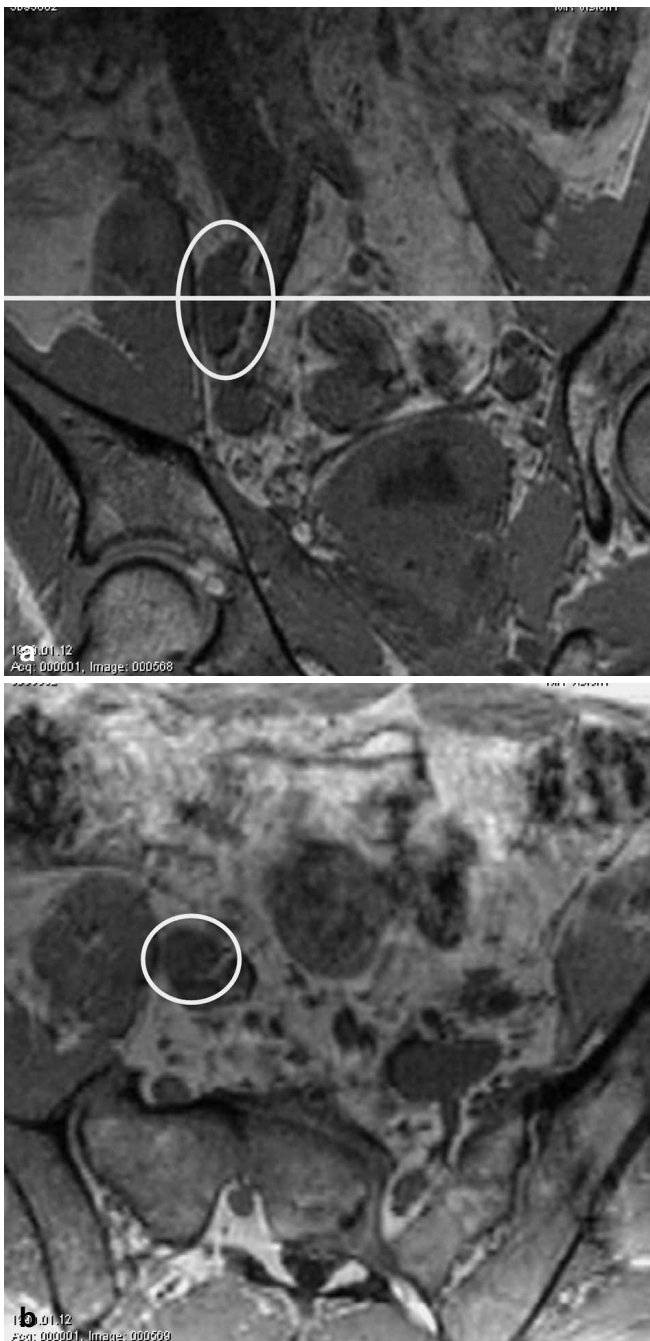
a, b. Three-dimensional T1-weighted MR images in oval enlarged lymph node metastases. Three-dimensional MP-RAGE reconstructed images in a angulated coronal, and b angulated axial plane, perpendicular to long axis of node (presented by *line* in a), allows nodal size evaluation in three dimensions (size = 3.2 × 1.3 × 1.2 mm; *circle*). Shape of node can also be determined. Surgery confirmed metastasis
